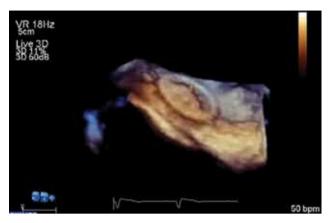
An Amplatzer PFO occluder visualized by 3D transcsophageal ultrasound.
